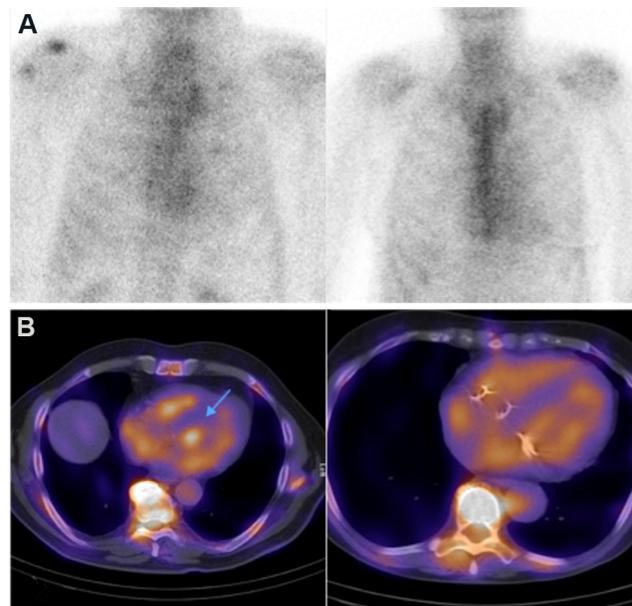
Technetium-99m pyrophosphate bone scan (A) 1 h planar images show mild tracer uptake on the cardiac area in two different patients; and (B) single photon emission computed tomography/computed tomography shows tracer uptake only in the cardiac chambers consistent for blood pool.
